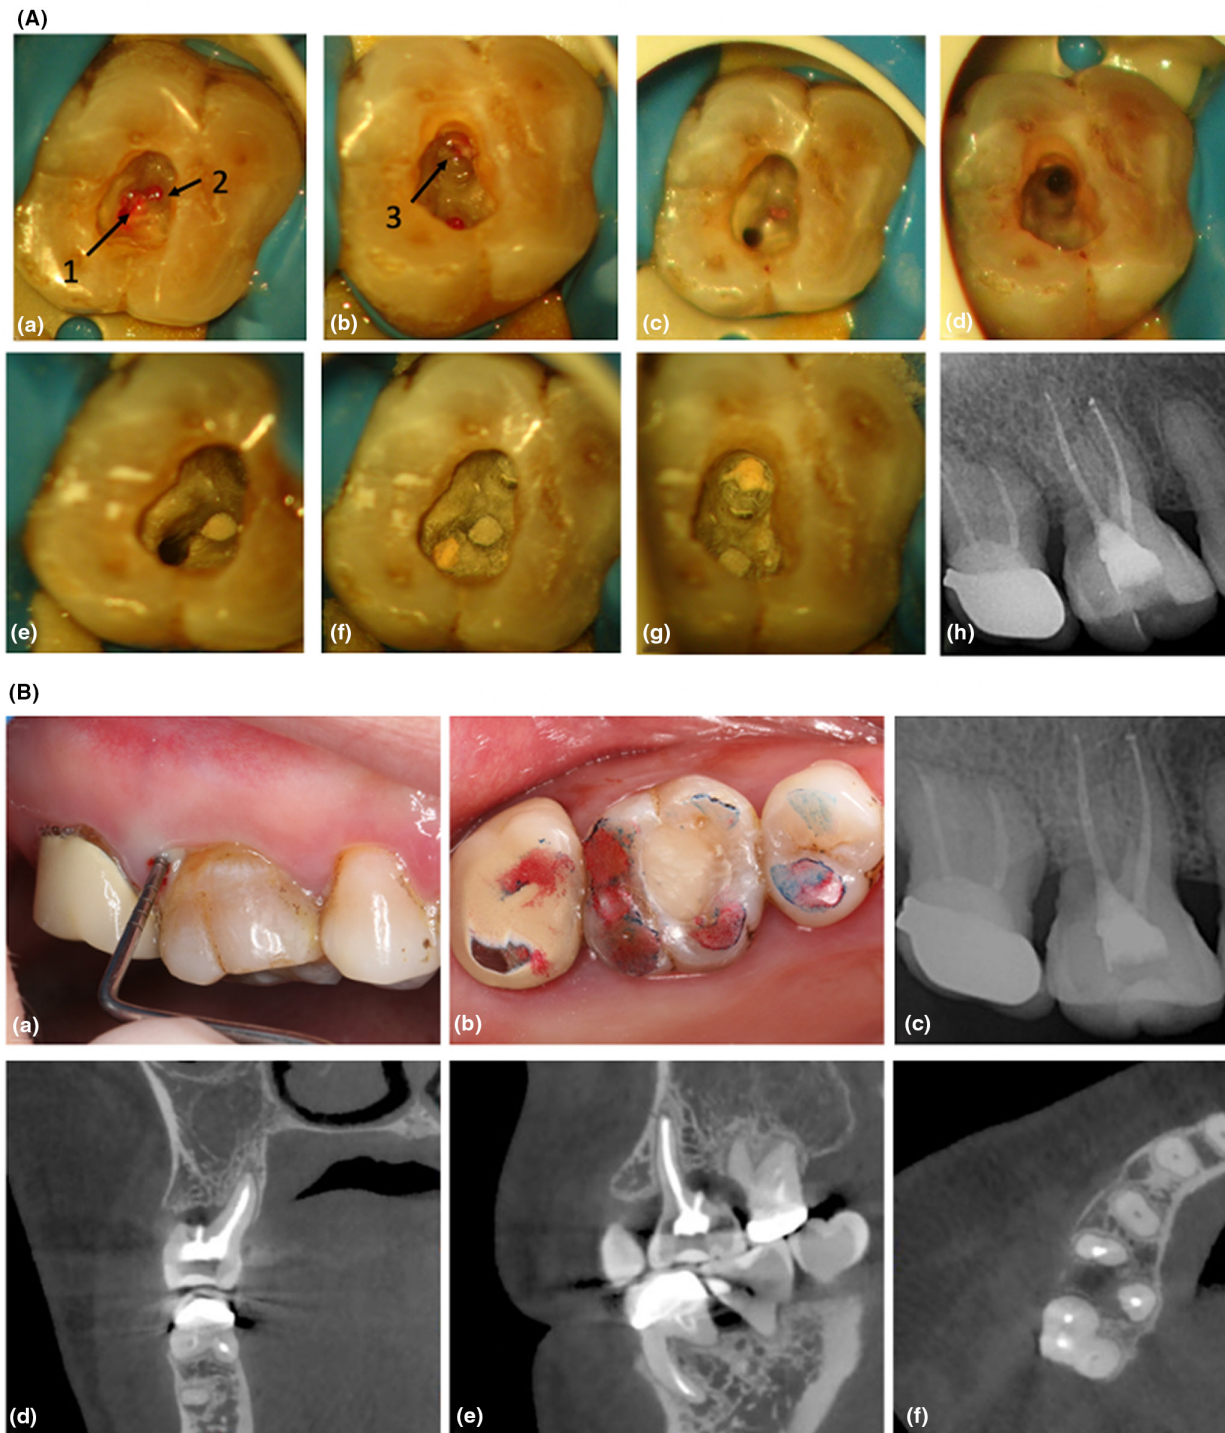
Root canal treatment of Tooth 16 and examinations 6 months after the root canal treatment. (A) Root canal treatment. (a, b) Access cavity preparation and expose the three root canal orifices. (1) Mesiobuccal. (2) Distobuccal. (3) Palatal. (c, d) Root canal preparation. (e) MTA filling of the distobuccal root. (f, g) Root canal obturation of mesiobuccal and palatal roots. (h) A radiograph taken immediately after root canal obturation. (B) Clinical and radiologic examinations were performed 6 months after the root canal treatment. (a) Horizontal probe. (b) Occlusal situation: blue: lateral occlusion; rad: central occlusion. (c) Apical radiograph. (d–f) CBCT. (d) Coronal scan. (e) Sagittal scan. (f) Axial scan.
